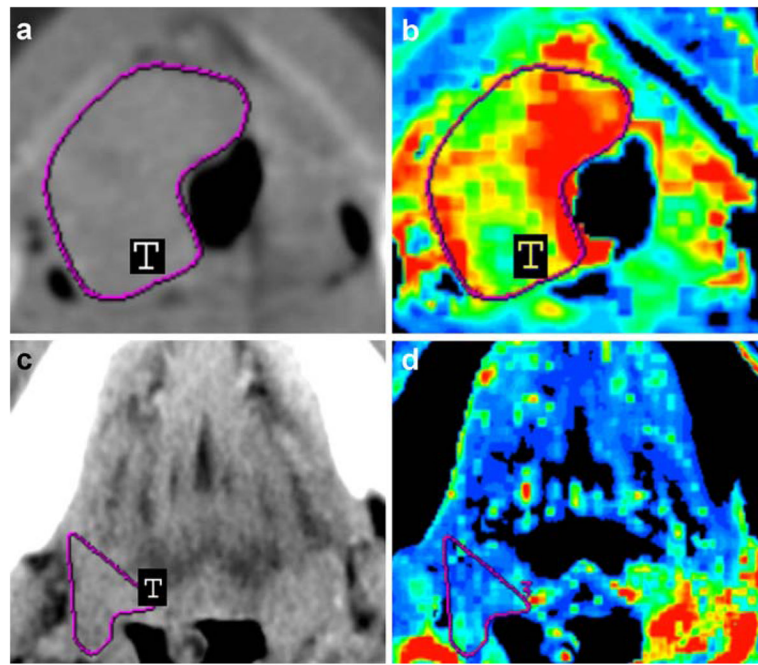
Contrast-enhanced neck CT scans (a, c) and CT perfusion maps (b, d) of a 45-year-old man with stage IV (*a–b*) and a 57-year-old woman with stage III (*c–d*) HNSCC in the base of the tongue. Solid tumor masses are indicated with T in (*a, c*). CT perfusion map (b) shows elevated blood flow (190.15 ml/100 g/min), which was confirmed by relative increased intratumoral MVD (47.2 vessels per square millimeter), whereas CT perfusion map (d) shows decreased blood flow (39.13 ml/100 g/min), which was confirmed by relative decreased intratumoral MVD (19.2 vessels per square millimeter). Reprinted with permission from [26]
